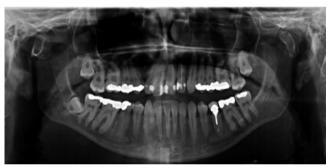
Bilateral fracture dislocation. The change in position of the condylar head results in greater visibility of its cortex on plain films. This results in a kidney-bean-shaped appearance to the head—an important clue. CT is required
